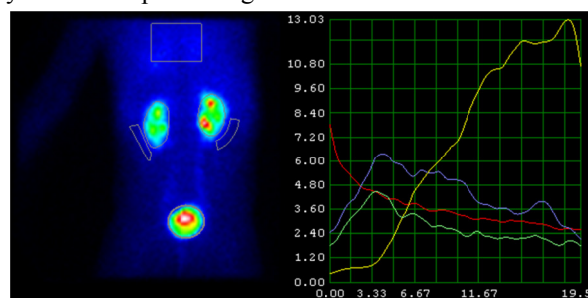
Dynamic nephroscintigraphy.
